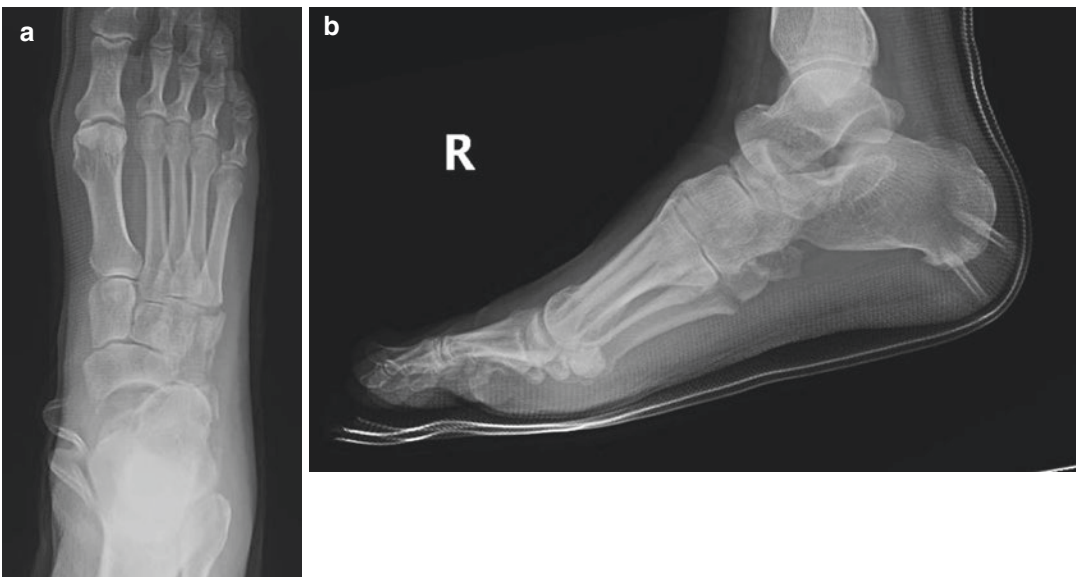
An AP (a) and lateral (b) X-ray demonstrates a medial subtalar dislocation with talar head shear fracture, anterior process calcaneus, cuboid, and fifth metatarsal fractures
